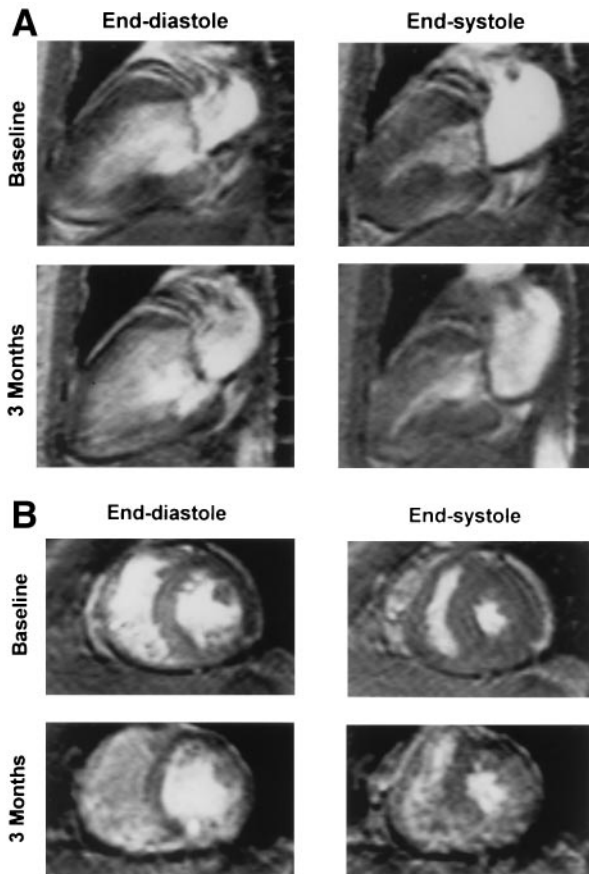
Long-axis (A) and short-axis (B) end-diastolic and end-systolic magnetic resonance images of the heart at baseline and 3 months after an anterior myocardial infarction in a patient randomized to receive ramipril. There is decreased wall thickening in the interventricular septum on the short-axis images. Note the decrease in LV wall thickness in noninfarcted myocardium at end-diastole, the increase in LV end-diastolic chamber size and the decrease in the LV mass/end-diastolic volume ratio as systolic wall thickening remains well preserved at the 3-month study in both long- and short-axis images.
